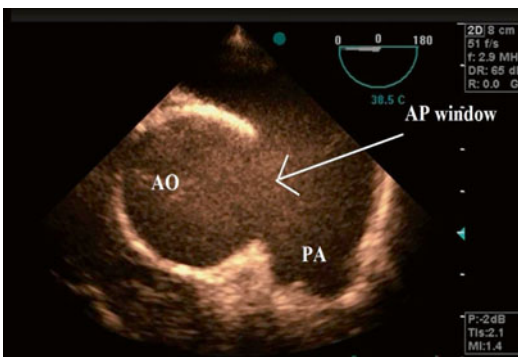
Aortopulmonary septal defect in transesophageal echocardiography (Video 52.3 and 52.4). AO aorta, PA Pulmonary artery
